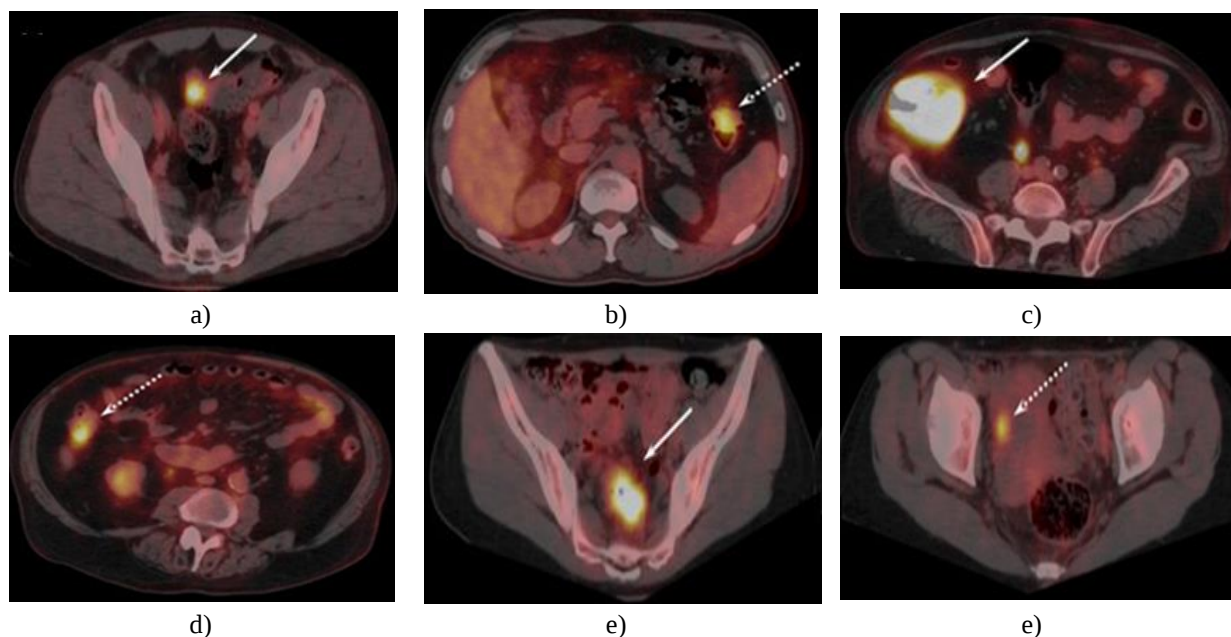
Preoperative ^{18}F -FDG PET/CT scans from three patients initially considered to have localized CC, revealing extra lesions or distant spread missed by routine staging (dotted arrows)
